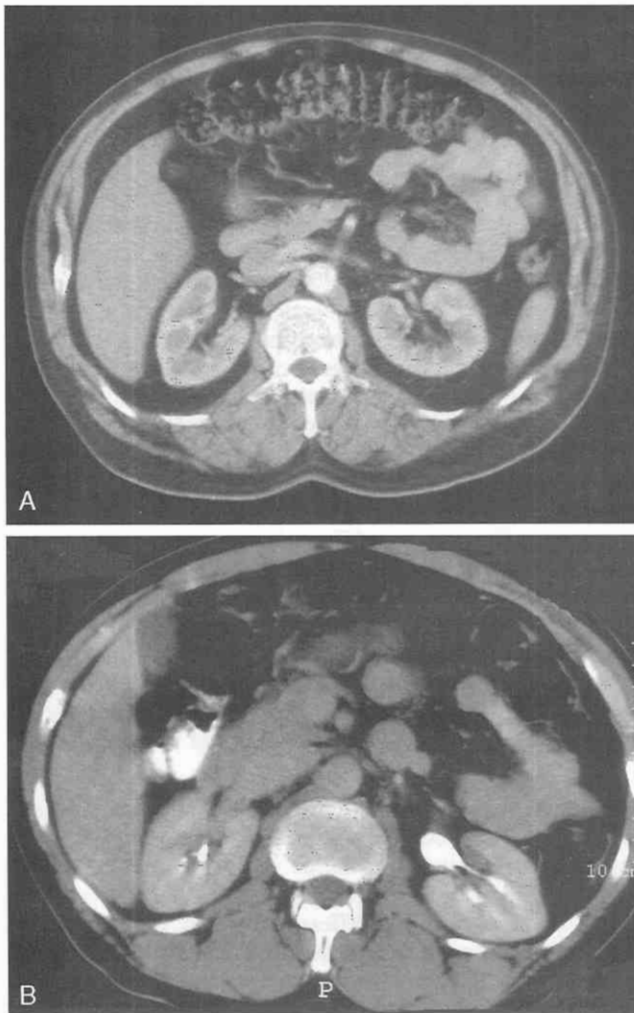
Normal CT. *A*, The corticomedullary phase demonstrates dense enhancing cortex with minimal enhancement of renal medulla. *B*, After a brief delay, the parenchymal enhancement becomes uniform, resulting in the nephrographic phase; in late nephrographic phase calyces may be opacified.
